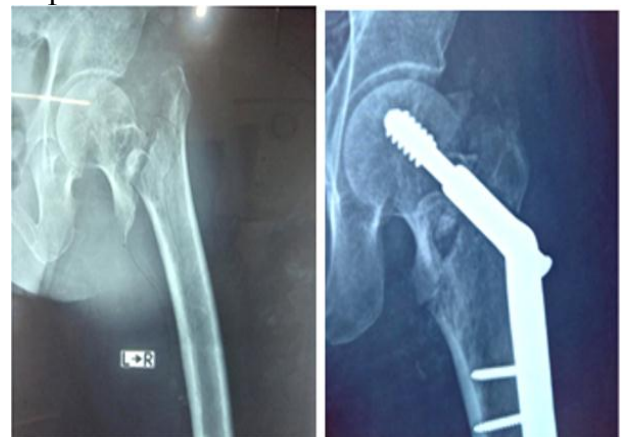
(a),(b), Pre operative X-ray showing unstable fracture left trochanter of femur., (b) Immediate post operative X-ray A/P view shows position of implant.
